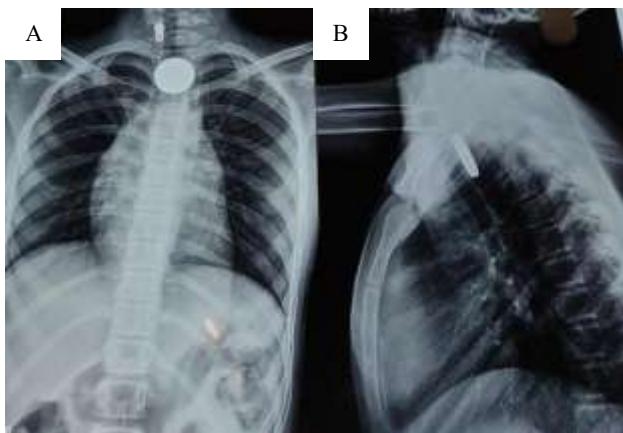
(A and B): Orthogonal plain films of case 1.
